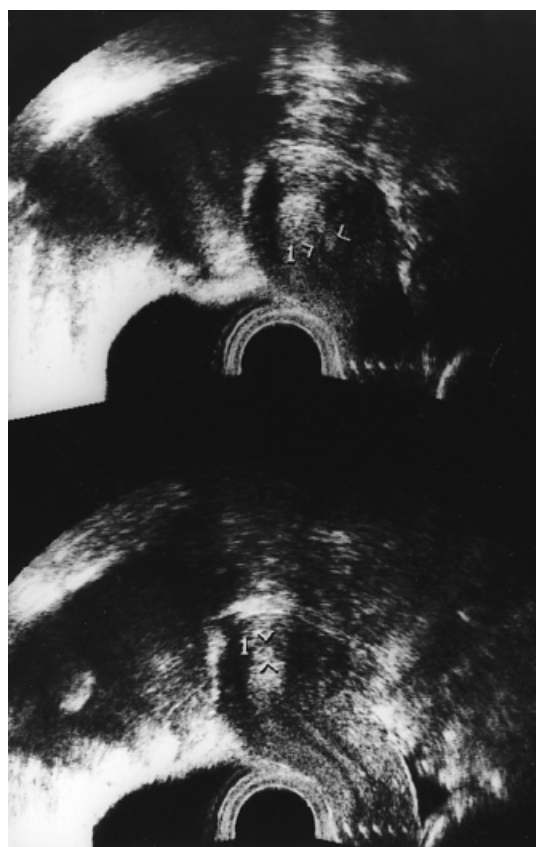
Vaginal sonography during the luteal phase of the cycle. The halo is disrupted with spots of high echogenicity in the posterior wall (top) and at the fundal part (bottom) of the uterus representing luteinized endometrial infiltrations.
